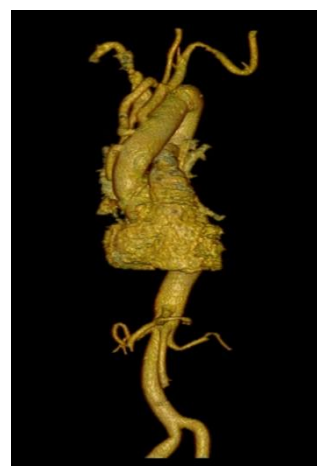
CT-scan showed no residual dissection of the ascending aorta
